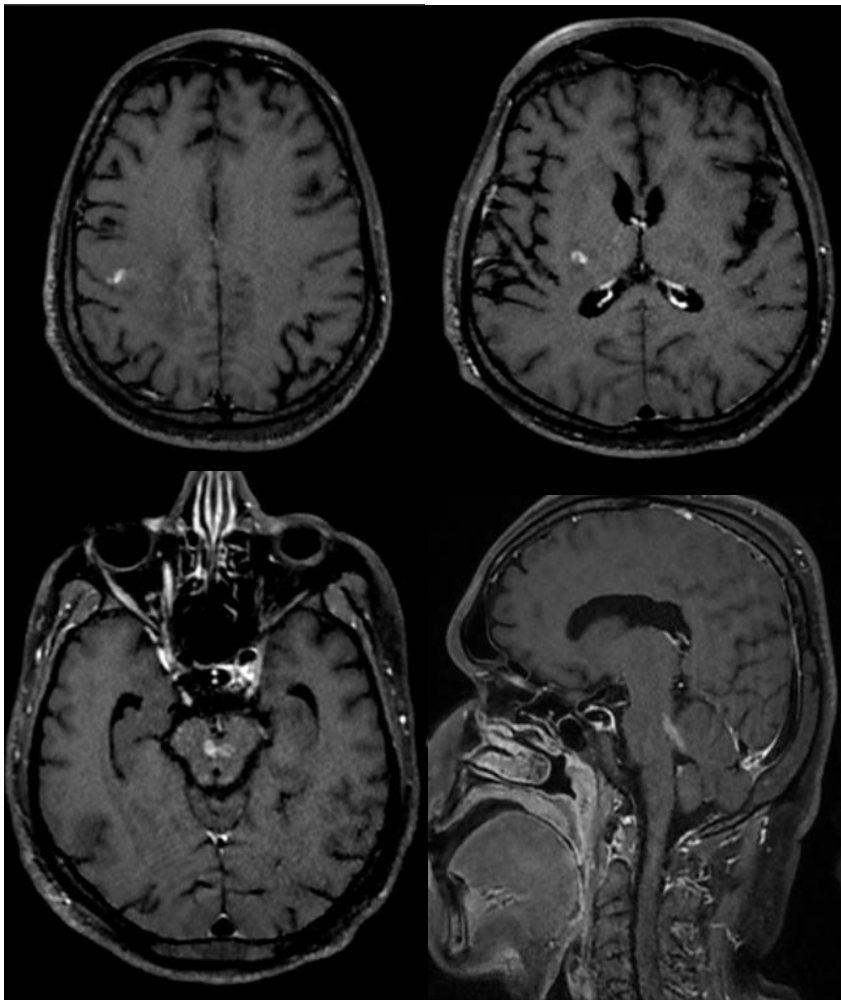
Contrast enhance MRI of the brain.
